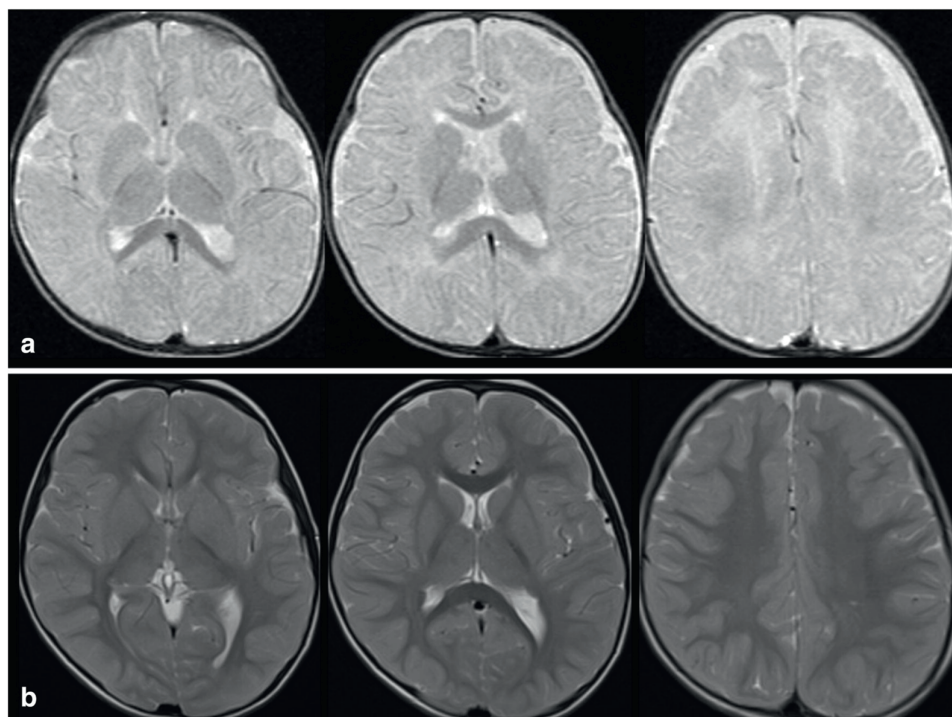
Brain MRI, T2-w.i. at 11,5 months (TOP) and at 4,5 years (BOTTOM) show delayed myelination at 1 years and the myelination progression until normal appearance at 4,5 years
